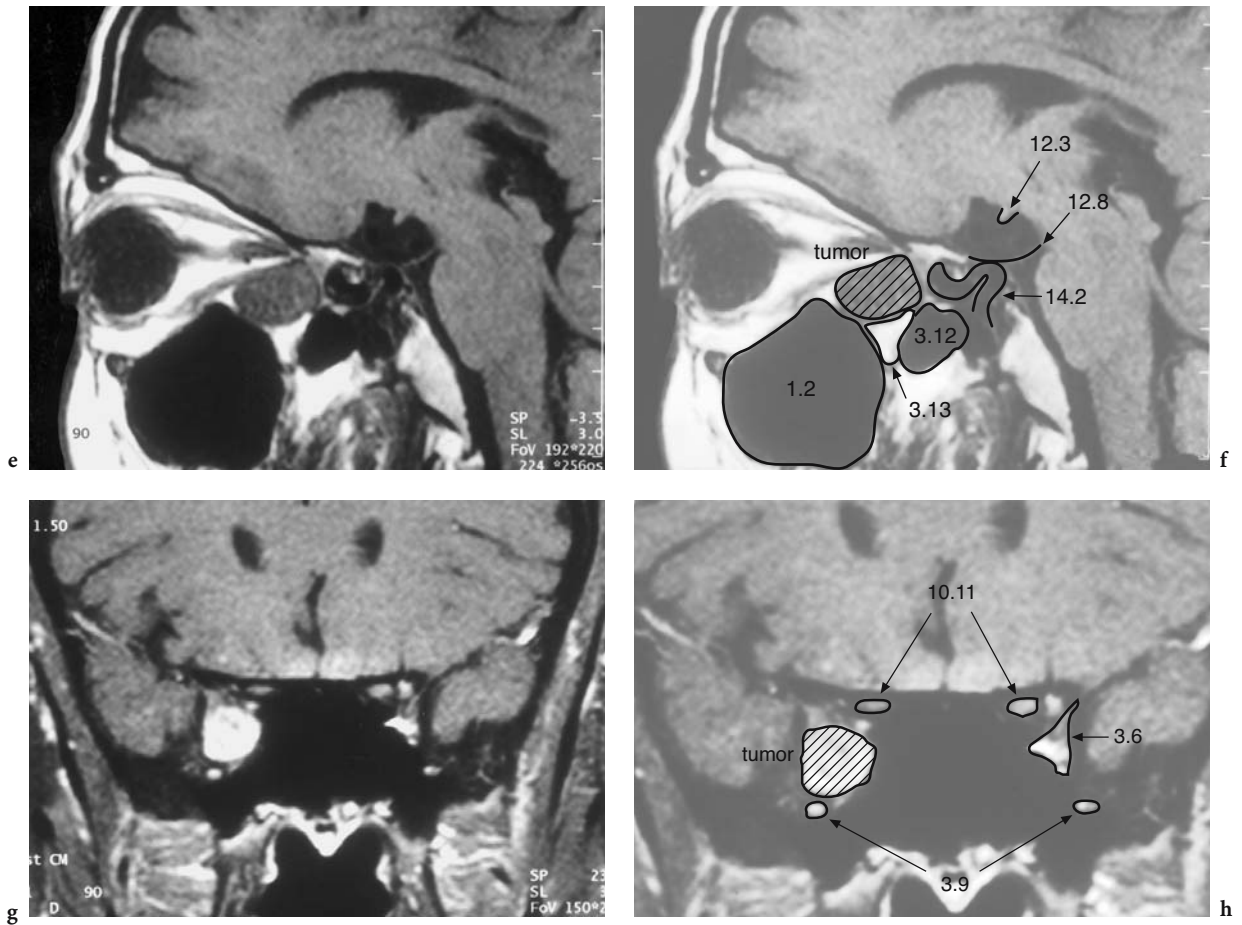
A 61-year-old woman with sudden vision loss 20 years ago, presenting for follow-up examination of the previously diagnosed mucocele. Diagnosis: suspected schwannoma of the superior orbital fissure. a Coronal conventional tomography (done 20 years ago) at the level of the optic canal (*arrows*) with biconvex widening of the superior orbital fissure (*triangles*). Current CT (bone window): b Corresponding coronal view to a, c Axial view, both demonstrating an extraconal, intraorbital mass located in the region of the superior orbital fissure, depressing the lateral wall of the (normally pneumatized) sphenoid sinus and causing widening of the lateral part of the sphenopalatine fossa. MR: d Axial T2-weighted view with a hyperintense
